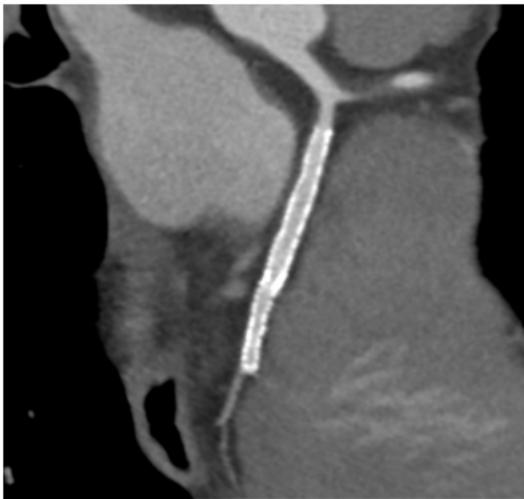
Curved multiplanar reformation CT coronary angiogram image showing good details of coronary stent lumen.
